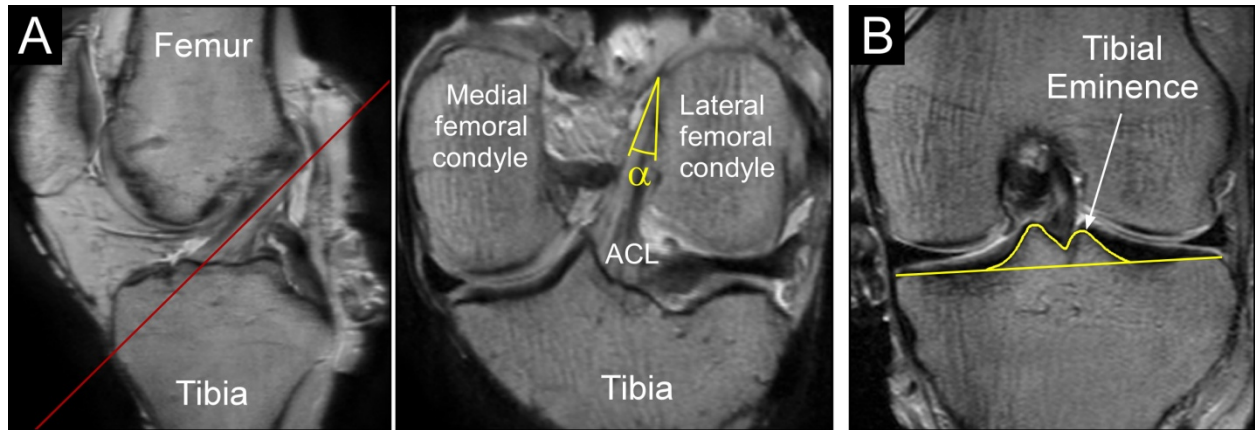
(A) Example of the femoral-ACL attachment angle measurement. Left: oblique-sagittal MR image showing the location of the oblique-frontal slice (red line, at mid-portion of the ACL) that was used to measure the angle. Right: oblique-frontal MR image showing the definition of the femur-ACL attachment angle (α). (B) Example of the tibial eminence (TE) measurement. Frontal plane MR image showing the outlined area of the TE, which was multiplied by the sum of the slice thickness and slice spacing to obtain each slice's TE volume. Total TE volume was calculated by taking the sum of the TE volume of all slices.
